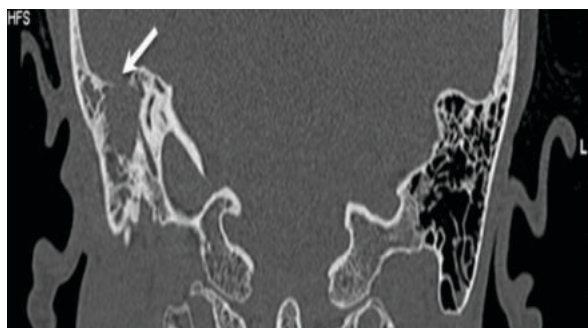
Coronal CT. Dehiscence of right tegmen tympani (arrow).
